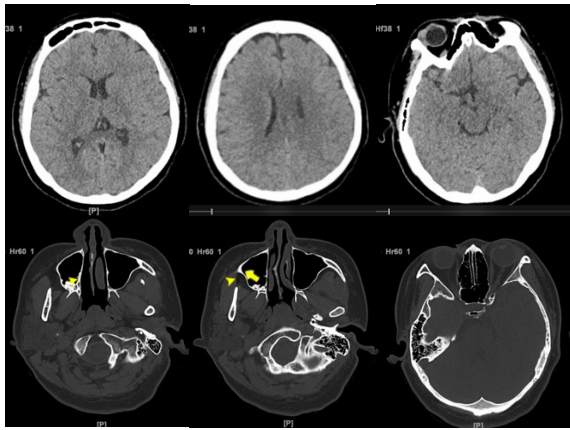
Brain CT scan without contrast, performed in 2023, showed bilateral thickening of the inferior nasal turbinates (yellow head arrow), suggestive of chronic rhinitis and a deviated nasal septum (yellow arrow). No signs of infarction, hemorrhage, or intracranial space-occupying lesions were observed
